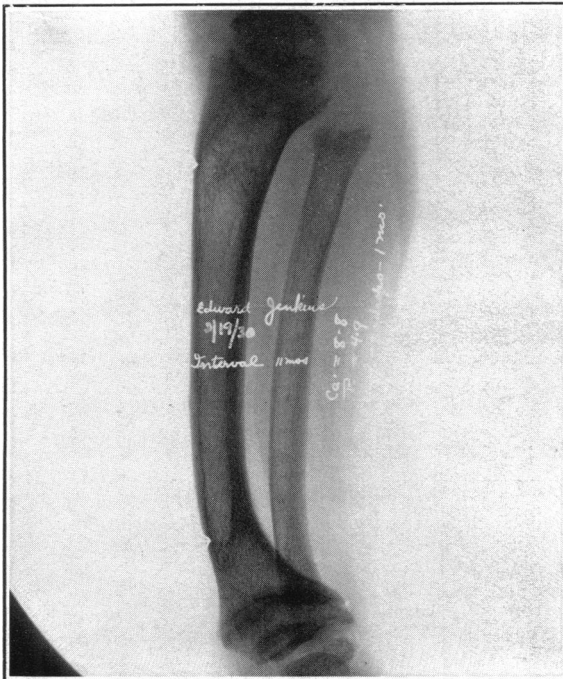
E. J. X-ray photograph of leg of same child as in Fig. 8 after an interval of 11 months. Note that this deformity is at higher level as the result of growth at the lower epiphysis. The deformity has really been pushed upwards and is now definitely above the ankle. The lower termination of the shaft of the tibia at the time when the rickets began is clearly outlined.
